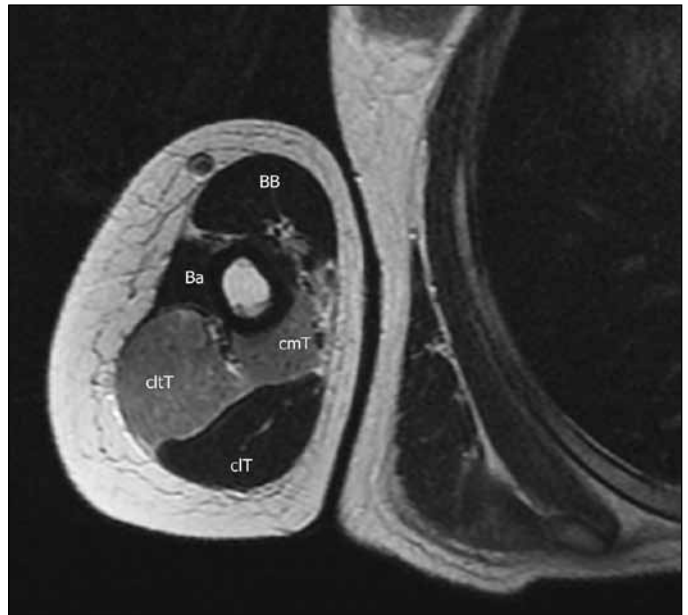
Arm's mid-third axial T2-weighted MRI (2320/86.3). That the radial nerve is compromised shows in the denervatory damage of the medial (Tmh) and lateral (Tlh) heads of the triceps muscle. Triceps' long head is undamaged, because it is usually innervated by the axilar nerve.
